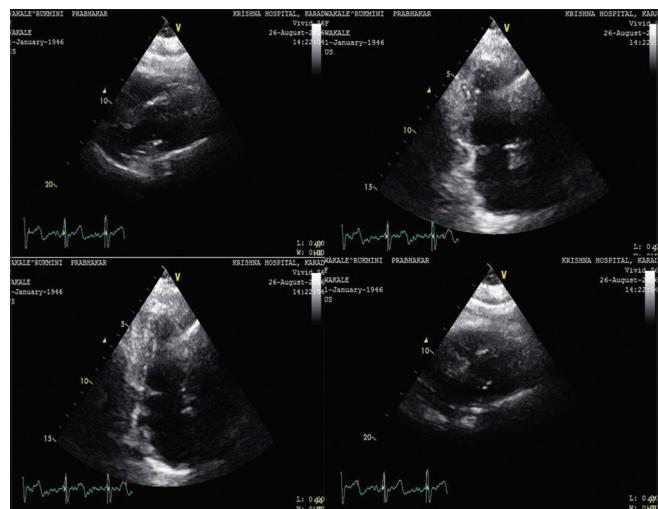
Two-dimensional echocardiogram later after 1 year (On August 26, 2016) – S/O No pericardial effusion with good left ventricle function
